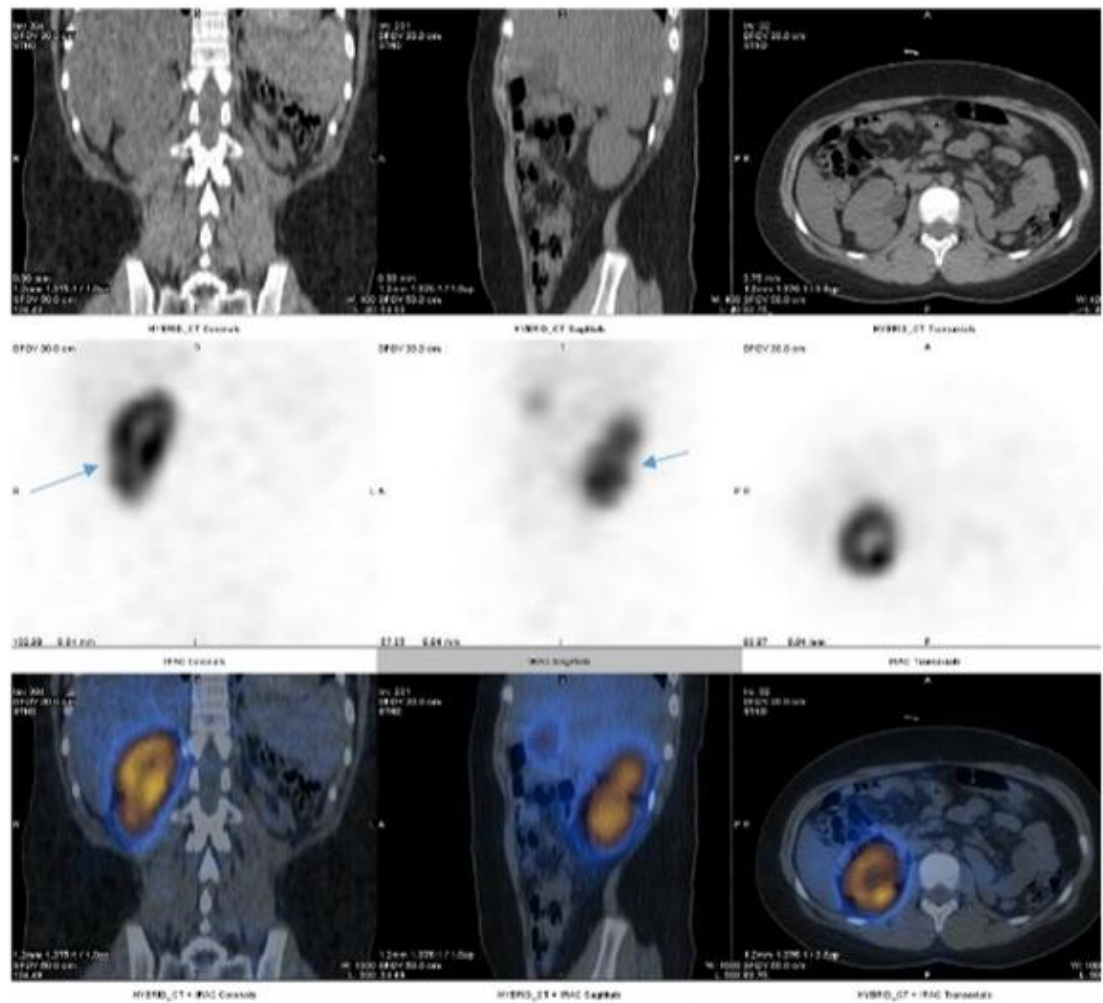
Cortical defect of the right kidney was also better visualized on the SPECT/CT images (arrows)
